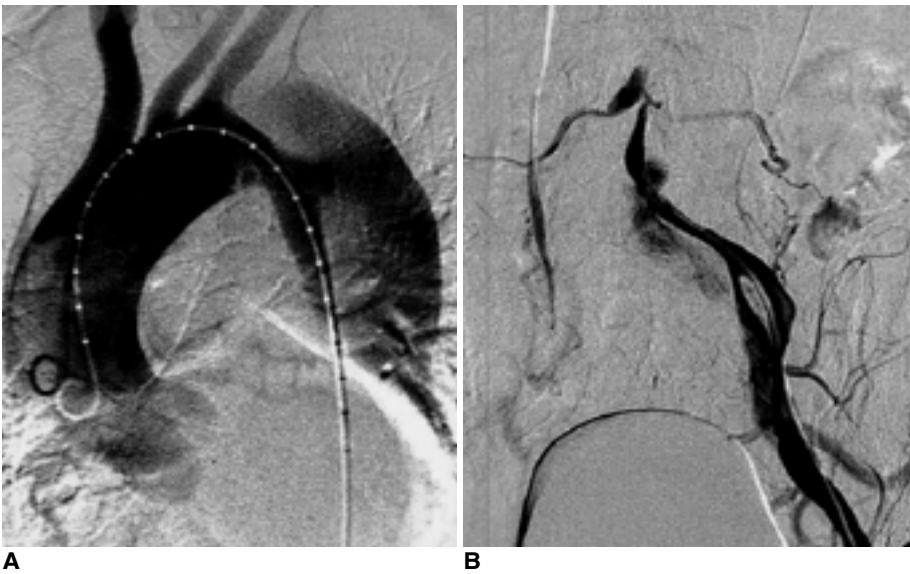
A. Entry tear is noted at descending thoracic aorta distal to the origin of left subclavian artery. B. Multiple reentry tears are identified at left common and internal iliac artery. C, D. Abdominal aortogram of true lumen(C) and false lumen(D). True lumen is compressed by false lumen and not visualized at the level of infrarenal aorta. Right common iliac artery is not visualized due to dynamic obstruction. E. On CT scan, the shape of true lumen is concave because of compression by false lumen.
